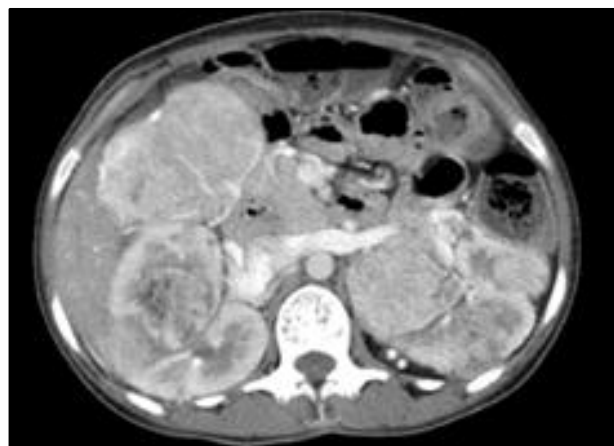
CT of Bilateral Angiomyolipoma in a Case of Tuberous Sclerosis
